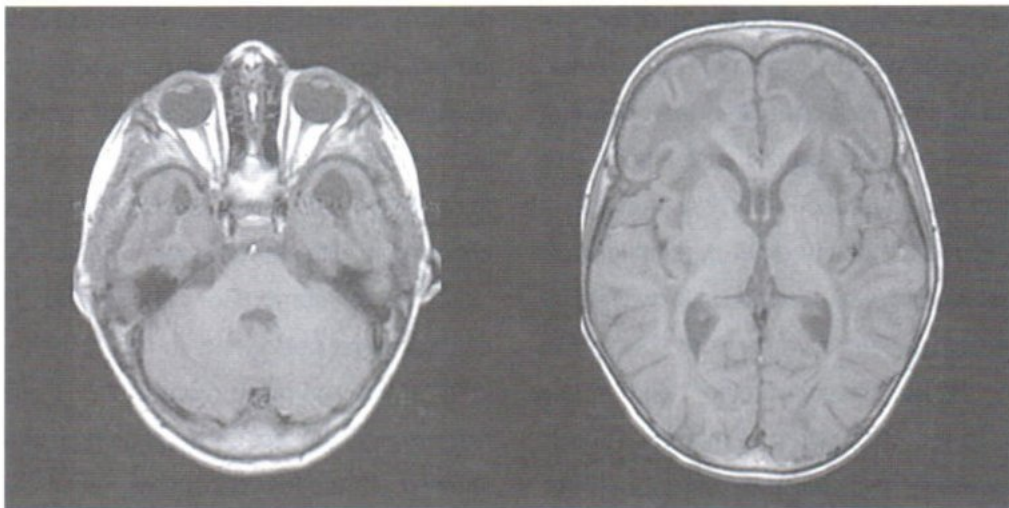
Axial T1-weighted images (TR.450 ms; TE.14 ms) shows diffuse T1 prolongation of the cerebral white matter predominantly at the frontotemporal lobes with anterior temporal subcortical cysts.
